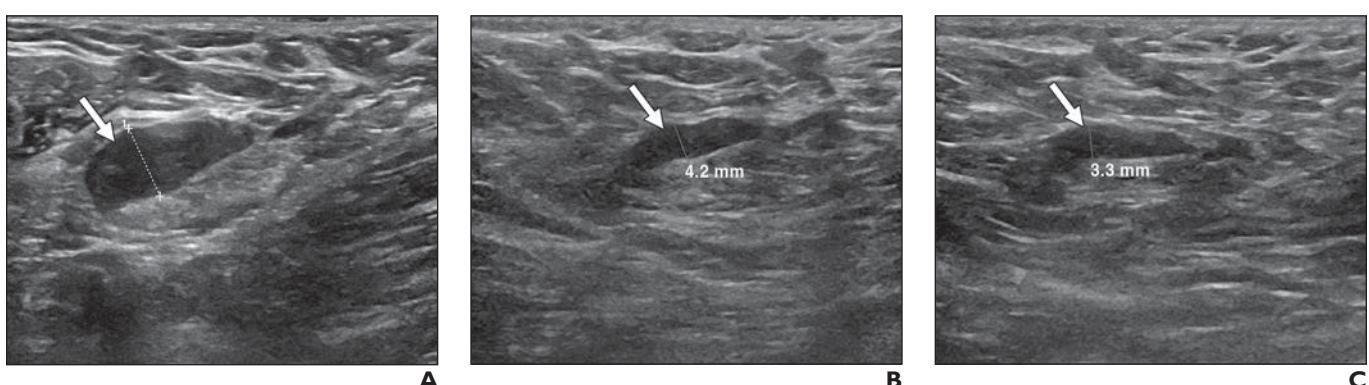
49-year-old woman undergoing screening breast ultrasound.
